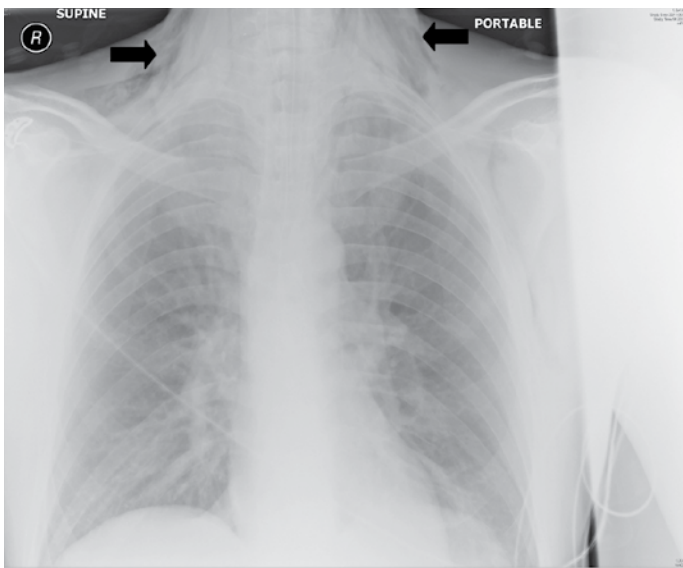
Chest X-ray of patient 3 shows surgical emphysema at the root of the neck bilaterally (black arrows)
